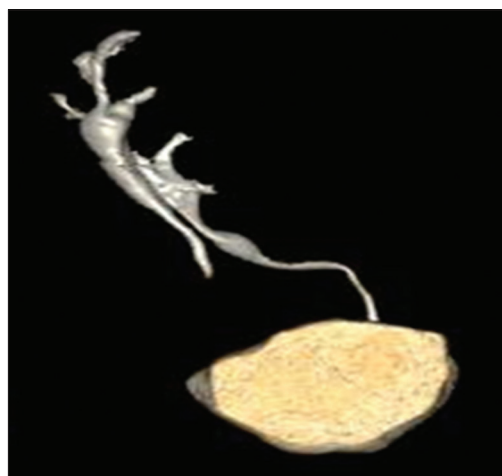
A volume-rendered multidetector computed tomography urography of the patient with crossed fused renal ectopia showing pelvicalyceal system and the ureters. The left ureter crossed the midline and open into the urinary bladder on the left side
